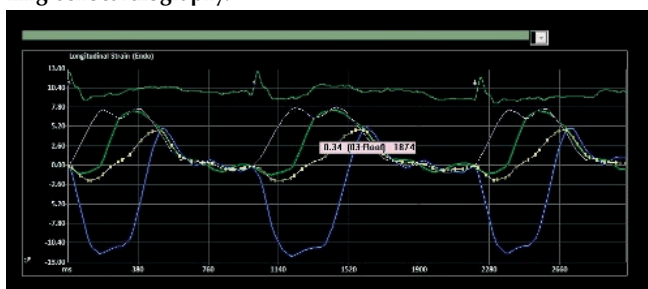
Evaluation of left atrial contractile strain by speckle tracking echocardiography.
